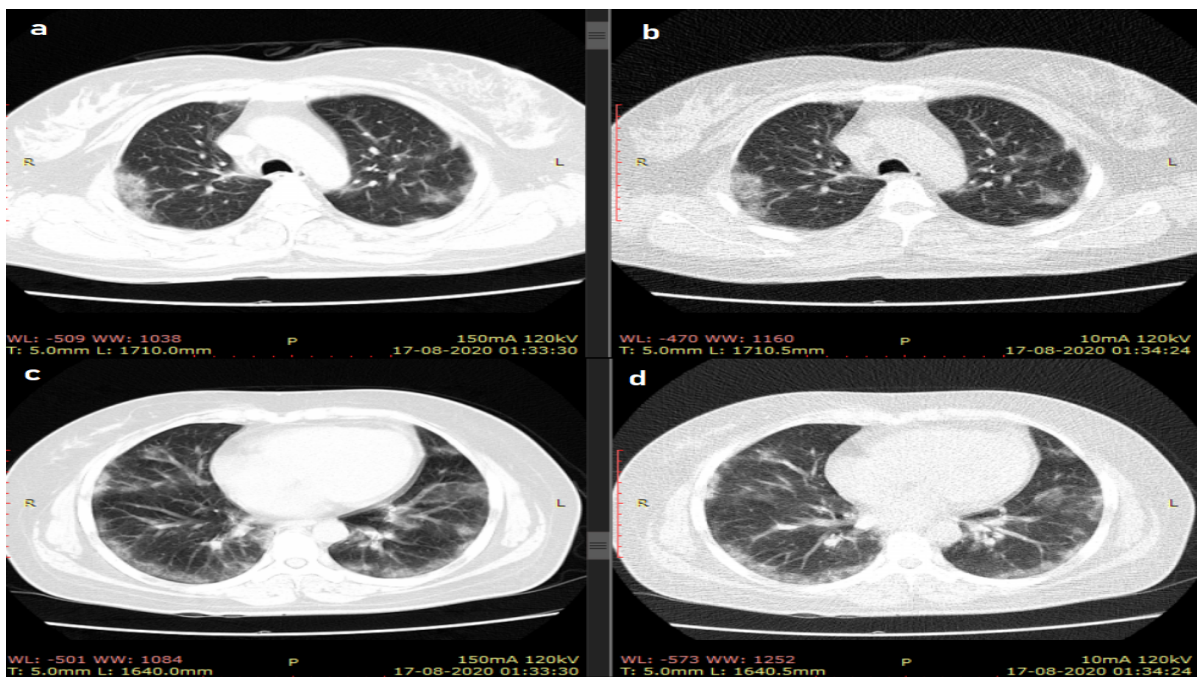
Chest CT Representation of COVID-19 Pneumonia Manifestations
